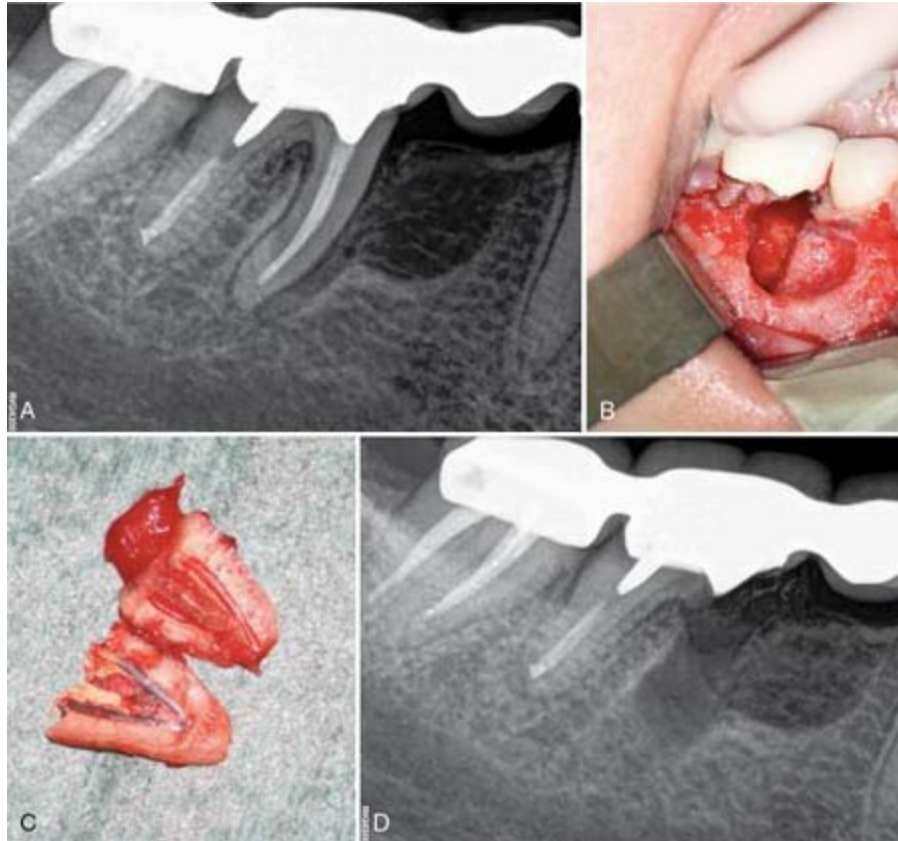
A, Periapical radiograph revealing bone loss from crestal bone to apex. B, As viewed clinically after full thickness flap. C, Mesial root resection performed and can see how the root has split. D, Final radiograph after mesial root resection.
